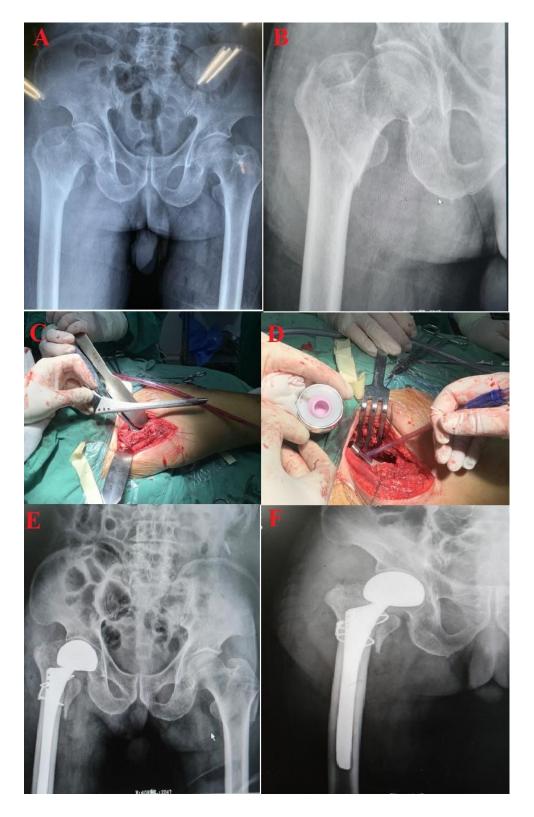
DAA Hip Arthroplasty for Intertrochanteric Fracture (Case 2). (A) Preoperative radiograph
